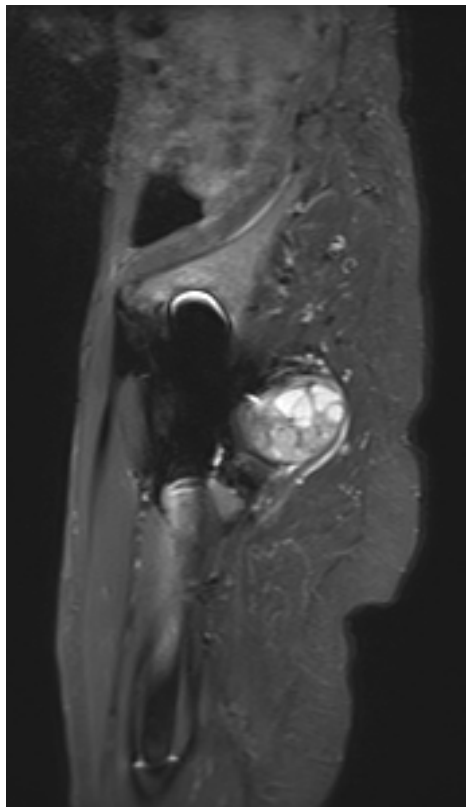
MRI showing a 4x4 cm left gluteal soft tissue mass
